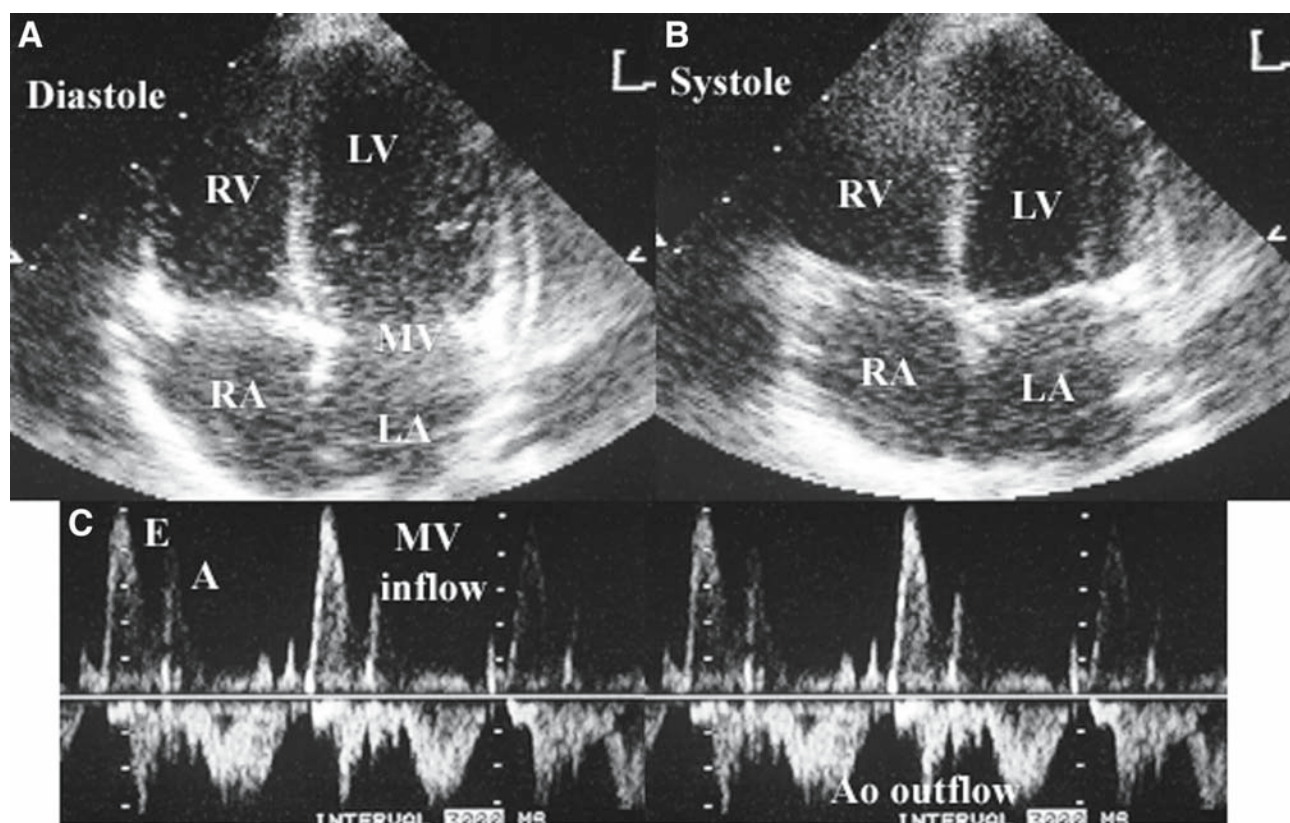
(A) Two-dimensional apical four-chamber view of the heart in diastole (open mitral valve). (B) Same imaging plane in systole (closed atrioventricular valves). The pulsed wave Doppler tracing (C) demonstrates mitral inflow toward the transducer (above the baseline) and aortic outflow away from the transducer (below the baseline). The mitral valve inflow tracing shows passive filling of the left ventricle during early diastole (E) followed by active filling of the left ventricle in late diastole with the onset of atrial contraction (A). Aortic outflow occurs in systole. LA, left atrium; LV, left ventricle; MV, mitral valve; RA, right atrium; RV, right ventricle.
